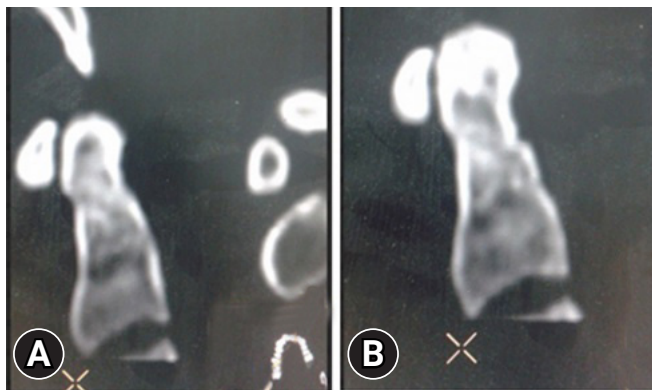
(A, B) A sagittal reformatted computed tomography scan of the cervical spine taken 3 months after treatment by external fixation. (A, B) Different sections show complete healing of the previously described complete irregular fracture at the base of odontoid process (C2).
